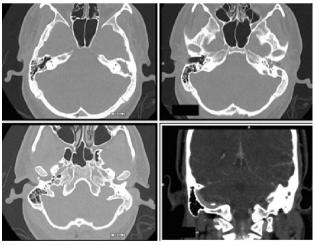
CT Temporal bone with thin cuts shows chronic left-sided otitis media and mastoiditis. Soft tissue opacification of left middle ear cavity and part of left external auditory canal with ossicular thinning and remodelling seen suggesting chronic otitis media. Spread of infection intracranially has caused cranial venous sinus thrombosis involving left transverse and sigmoid sinuses with resultant epidural abscess formation and left posterior parietal intraparenchymal abscess.
